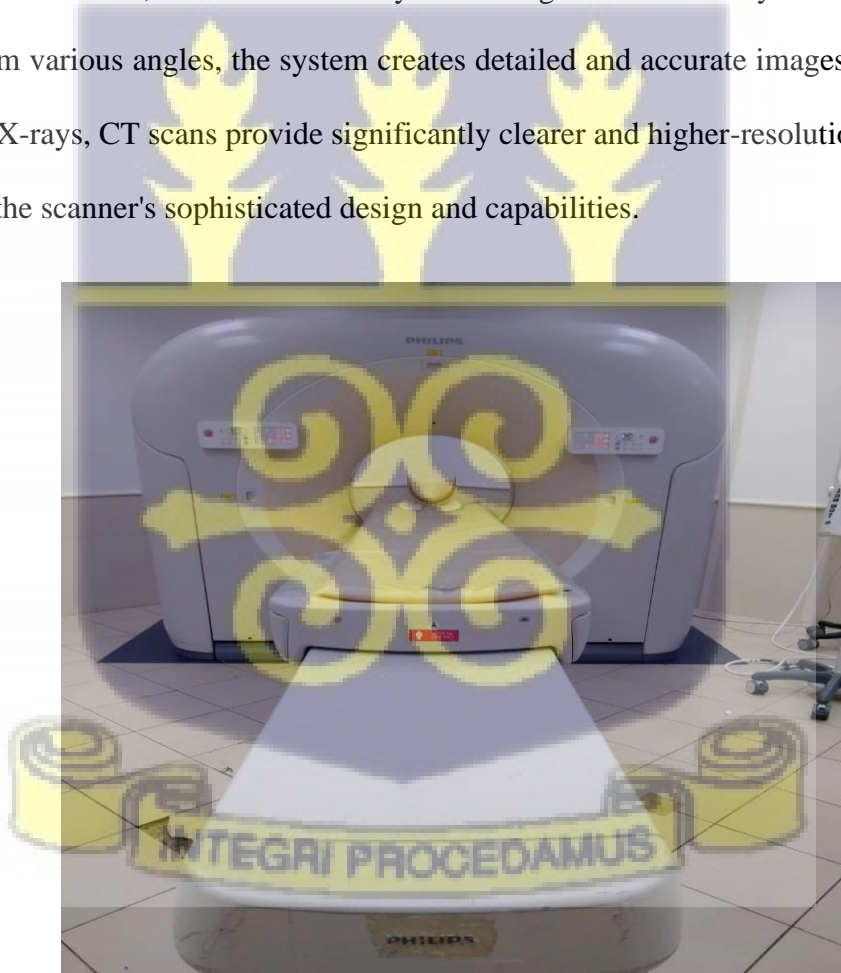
3: the Philips computed tomography (CT) scanner at the UGMC facility.
